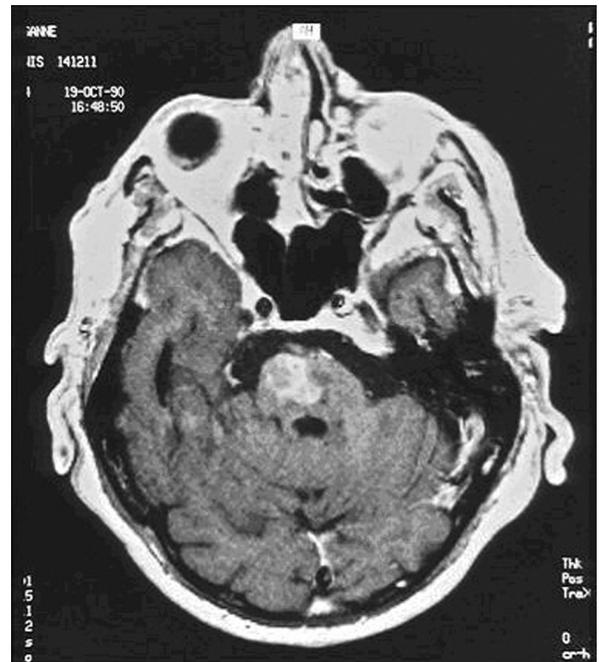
Bilateral pontine infarction (MRI T2-weighted imaging).
